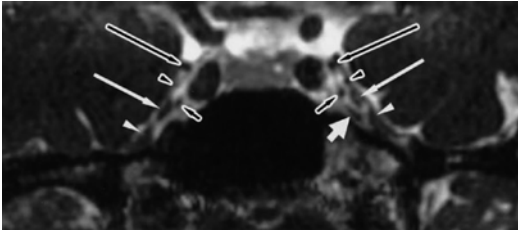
Coronal view shows bilateral oculomotor (*long black arrow*), trochlear nerve (*black arrow head*), ophthalmic nerve (*long white arrow*), maxillary nerve (*white arrow head*), and abducens nerve (*short black arrow*) [Reprinted from Yagi, N. Sato, A. Taketomi, T. Nakajima, H. Morita, Y. Koyama, J. Aoki, and K. Endo. Normal cranial nerves in the cavernous sinuses: contrast-enhanced three-dimensional constructive interference in the steady state MR imaging. *AJNR. Am. J. Neuroradiol.* 2005;26(4): 946–50. With permission from Williams & Wilkins Co.]
